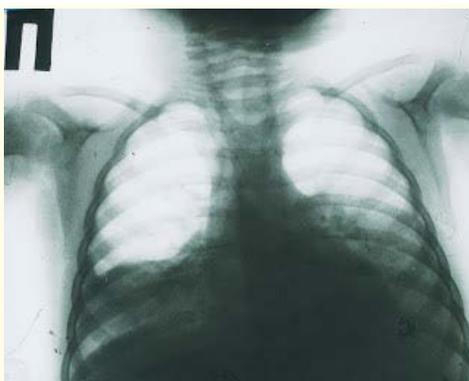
X-ray photograph of a 22-month-old patient, 24 hours after starting ABP clinic. Intensive homogenous shading in basal sections of both lungs with moderate thickening of pleura in the left lung.
